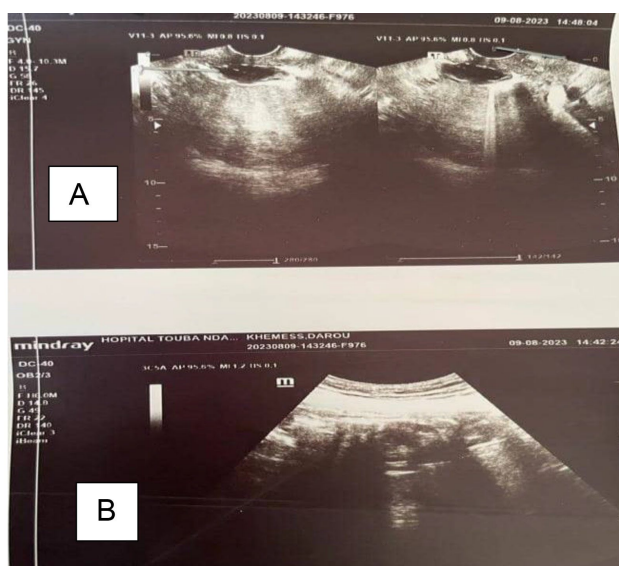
Ultrasound image of a discontinued abdominal pregnancy. (A): empty uterus; (B): fetal death outside the uterus.
